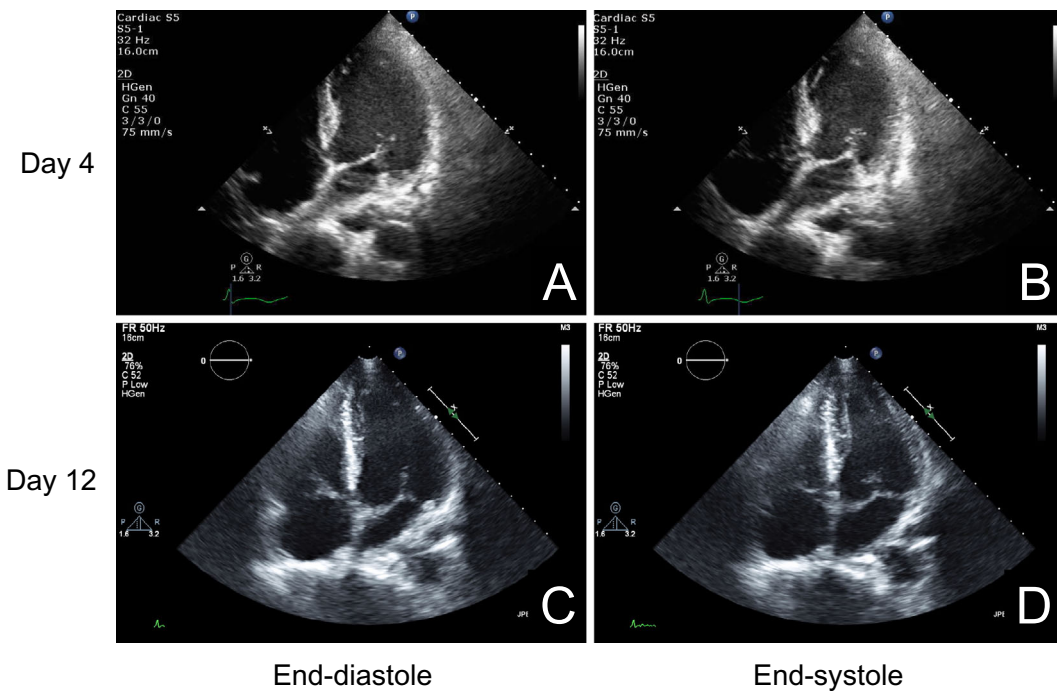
Apical four-chamber views of transthoracic echocardiography on day 4 (A and B) and day 12 (C and D) after admission. A and C, end-diastole; B and D, end-systole.
